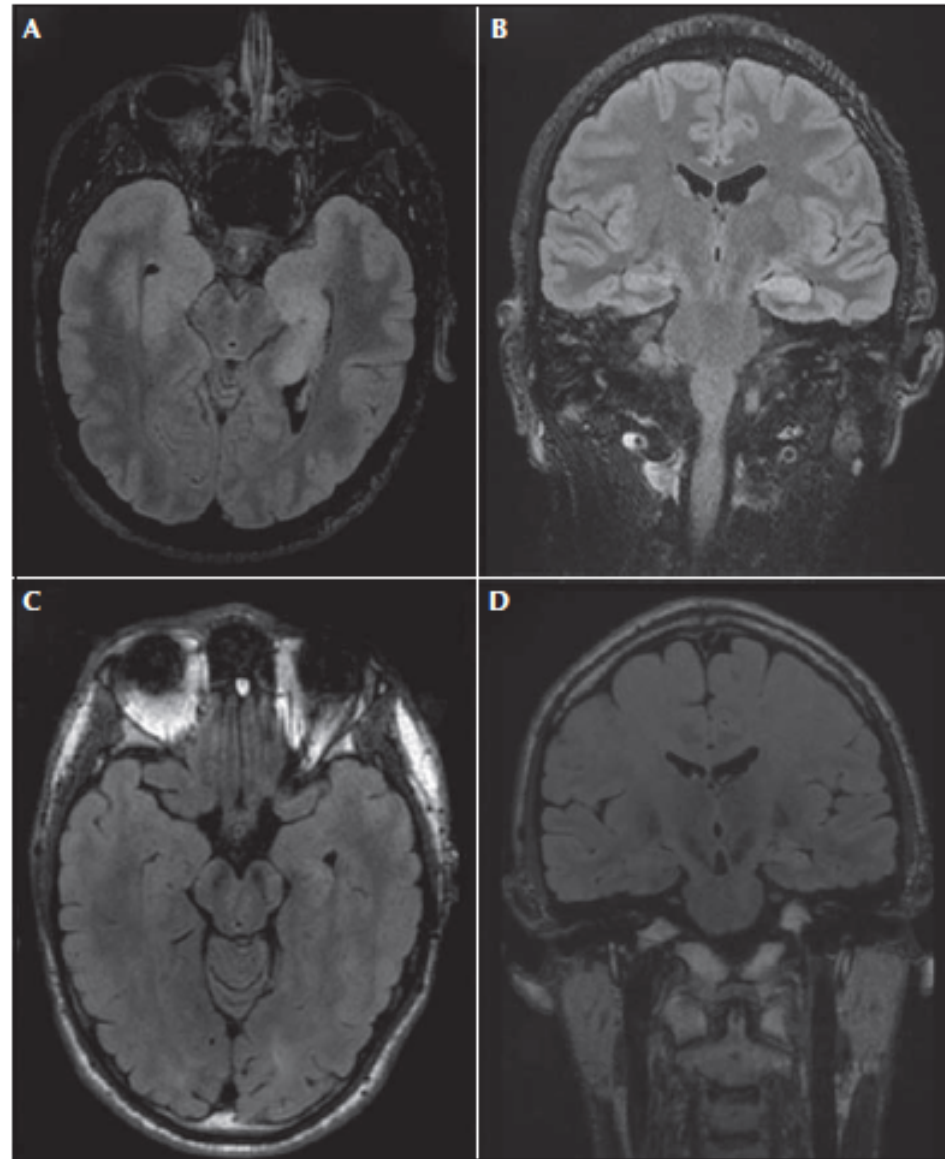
MRI series demonstrating limbic encephalitis and recovery seven months later, using T2-FLAIR brain MRI. (A) Day 15 after presentation, axial-view. (B) Day 15 after presentation, coronal view. (C) Month 7 after presentation, axial-view. (D) Month 7 after presentation, coronal view. (A, B) Asymmetric enlargement and T2 hyperintensity of the left more than the right hippocampus which may represent limbic encephalitis vs. postictal oedema. (C, D) demonstrate resolution of previous T2 hyperintense T2 signal seven months later.
